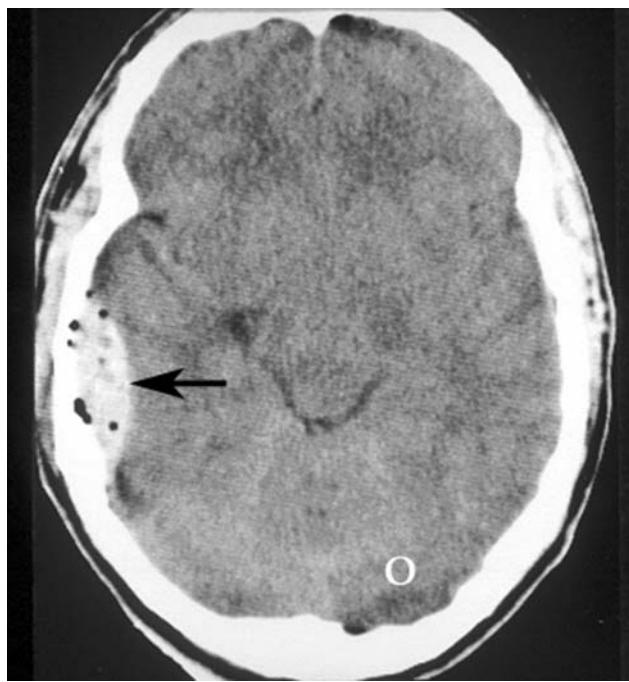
A CT scan revealing a developing epidural hematoma (arrow) that covers part of the right cerebral cortex. Note that the fresh blood has a much brighter CT signal than the blood seen in a chronic subdural hematoma (see Fig. 24). The black circles in the epidural hematoma represent air leaking in from the skull fracture. Epidural hematomas most commonly result from tears in the middle meningeal artery. Thus, this is the most common position to image an epidural hematoma. Epidural hematomas present as a lens-shaped lesion on a CT scan and do not cross suture lines. O, occipital lobe.
